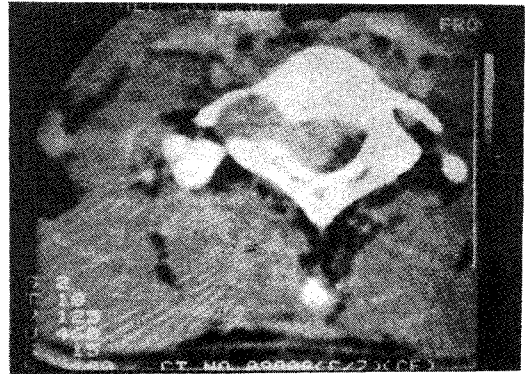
Cervical spinal CT scan prior to operation : there is evidence of a dumb-bell shaped mass on the right intervertebral foramen through the level of C-7 and T-1, and the spinal cord was deviated to the left side due to the mass.
